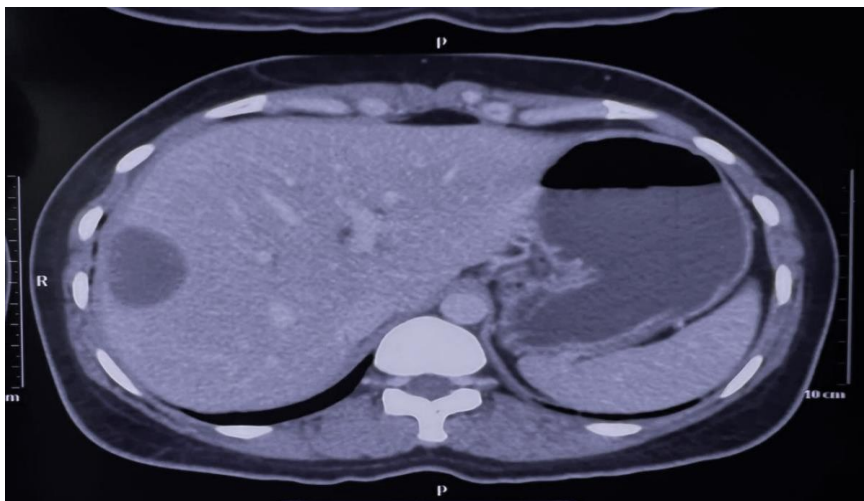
Contrast CT scan of abdomen: hypodense lesion in the right lobe of liver
